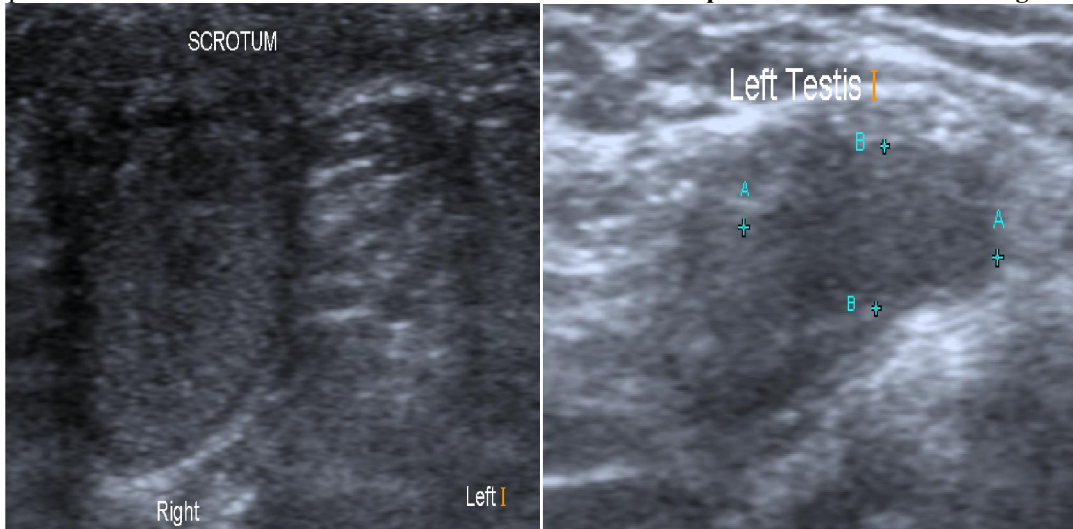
Abdomino-pelvic and scrotal ultrasound revealed empty left hemi-scrotum with left testis in the left inguinal canal associated with inguinal hernia.
